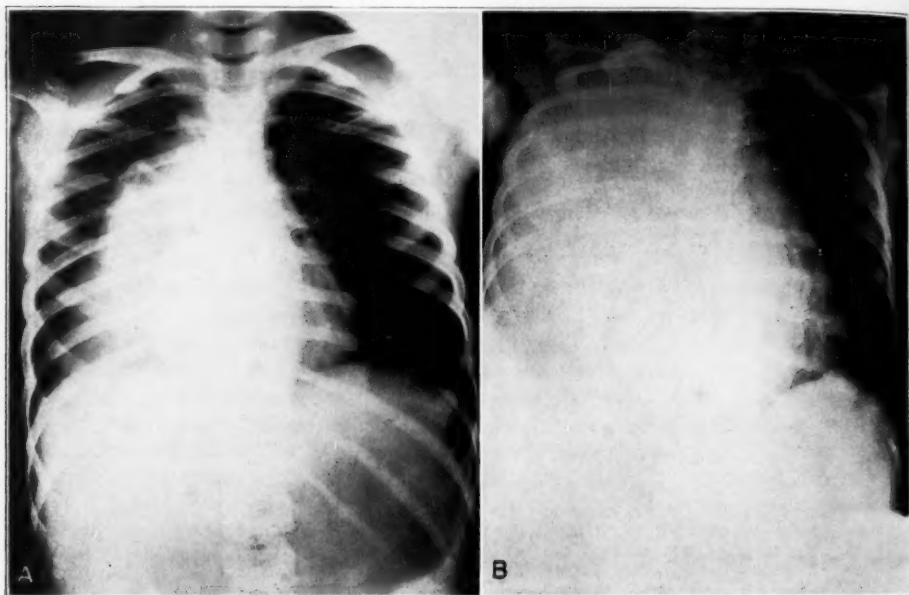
(case 14).—*A*, roentgenogram showing a tumor mass in the right side of the chest associated with an extradural tumor which produced a paraplegia. *B*, same as *A*, taken at a later date, showing the great increase in the size of the tumor of the chest.
